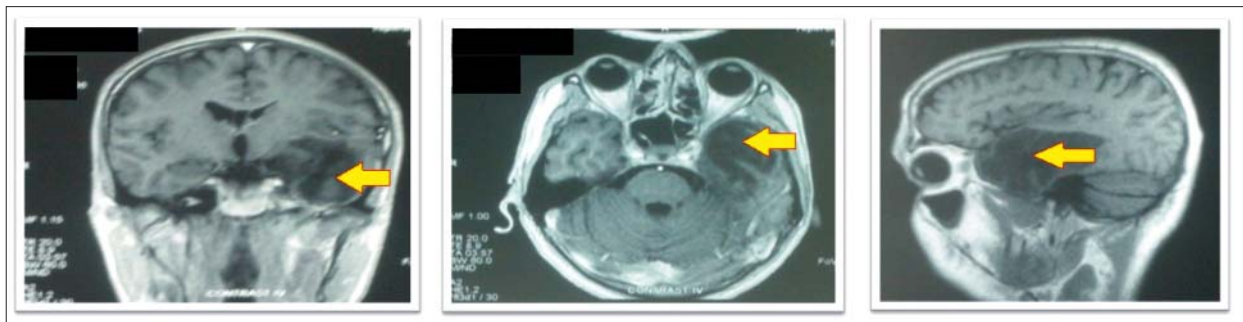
Conventional MRI in a patient with low grade glioma
